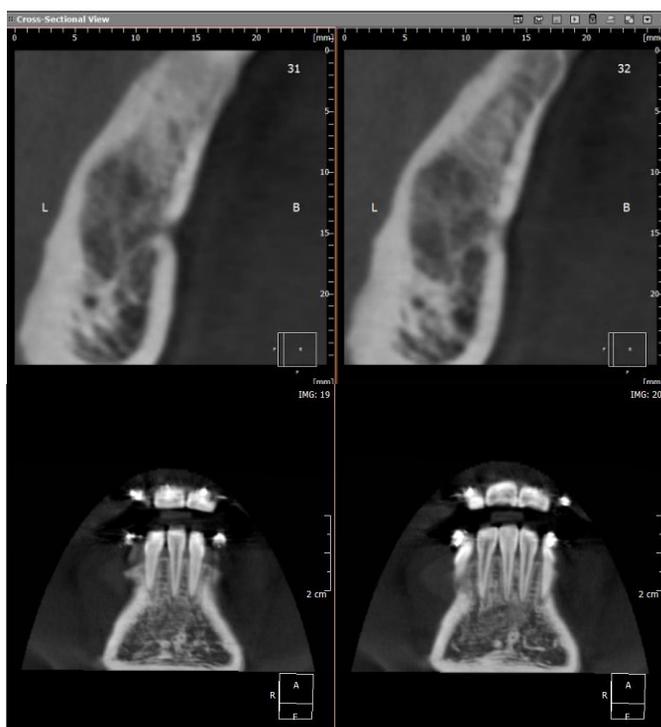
CBCT scan exhibited radiopacity in the region of the lesion, suggestive of bony fill and normal healing.
